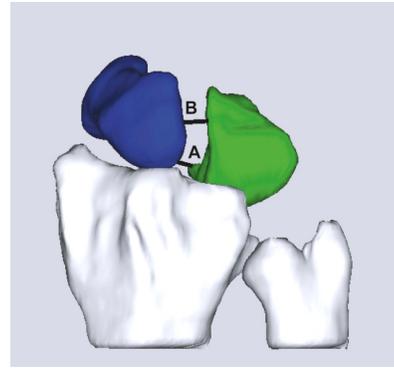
1D gap as on an X-Ray
